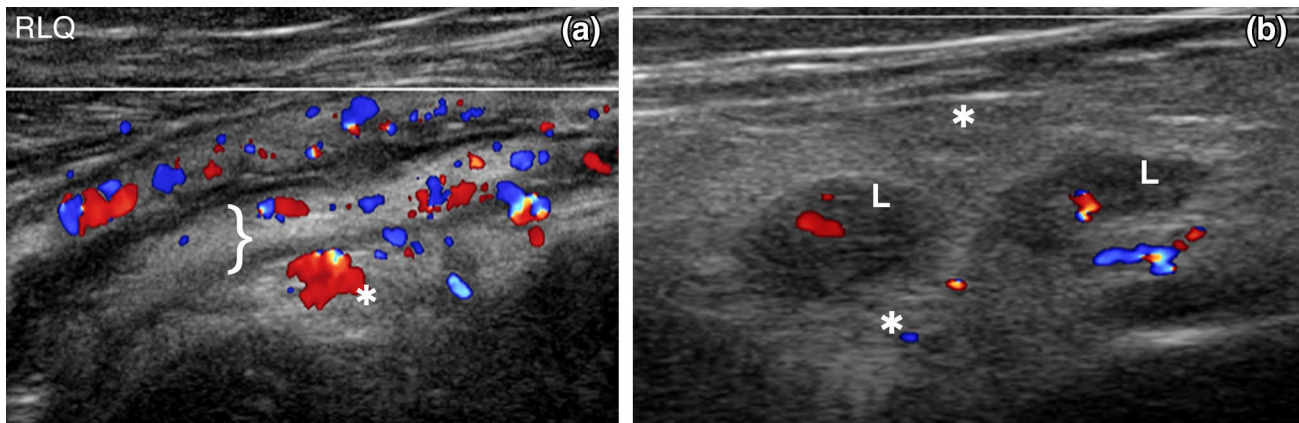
Infectious colitis in a 35-year-old female with 2 days of diarrhea and RLQ abdominal pain who recently returned from vacation in the Dominican Republic. She had prior negative work up for IBD. a Longitudinal and b transverse color Doppler images of the right lower quadrant demonstrate marked thickening of the echogenic
